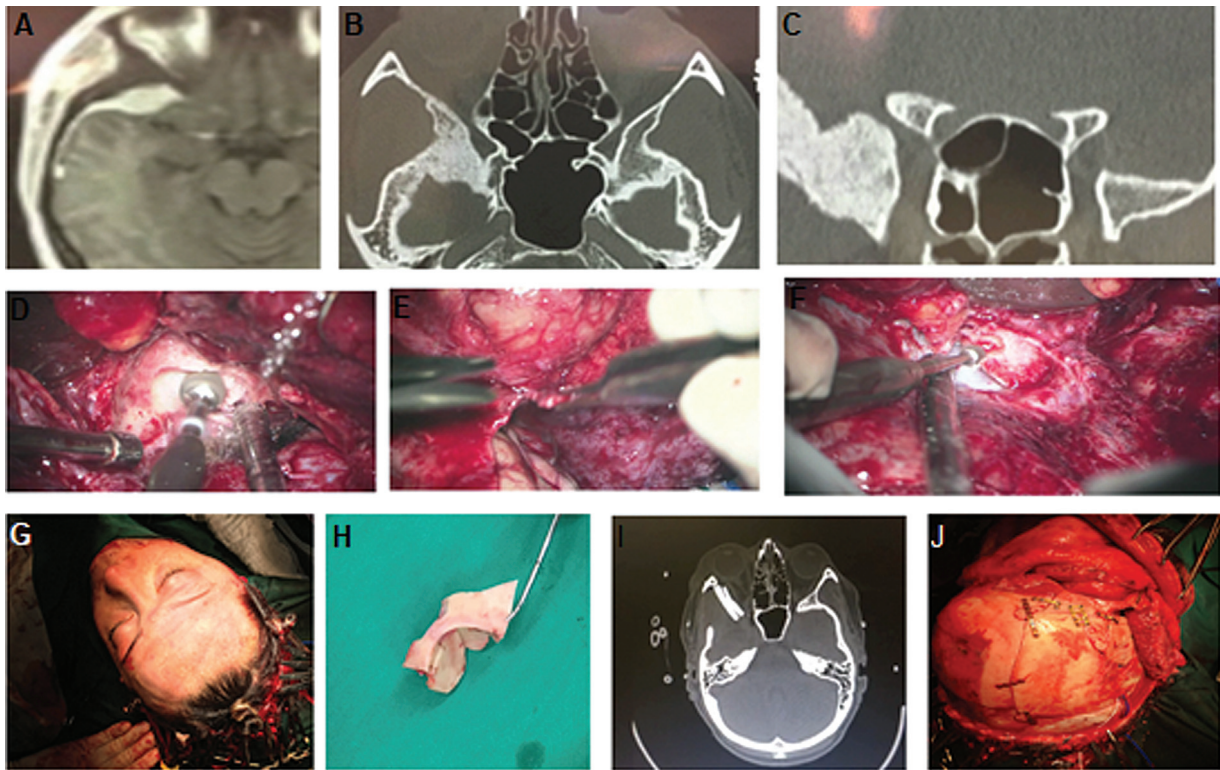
A multidisciplinary approach is crucial to acquire good results in skullbase surgery. In this case, an en-plaque sphenoid wing meningioma was resected by the neurosurgical team while the cranial and orbital reconstruction was performed by the craniofacial surgery team. (A) magnetic resonance imaging (MRI) showing an en-plaque meningioma; (B) axial computed tomography (CT) scan showing a hyperostosis of the pterygoid plate; (C) coronal CT scan showing large hyperostosis not only of the pterygoid plate but also in the anterior clinoid process; (D) intraoperative view of the hyperostotic anterior clinoid process being drilled; (E) intraoperative view of the reconstruction of the lateral and superior orbital walls; (F) intraoperative view of the cranial reconstruction using the inner table of the parietal bone; (G) patient's position; (H) orbital wall reconstruction with parietal bone flap; (I) postoperative CT scan showing a part of the inner table of the parietal bone that was placed in the lateral wall of the orbit to avoid enophthalmos; (J) final cranial reconstruction.
